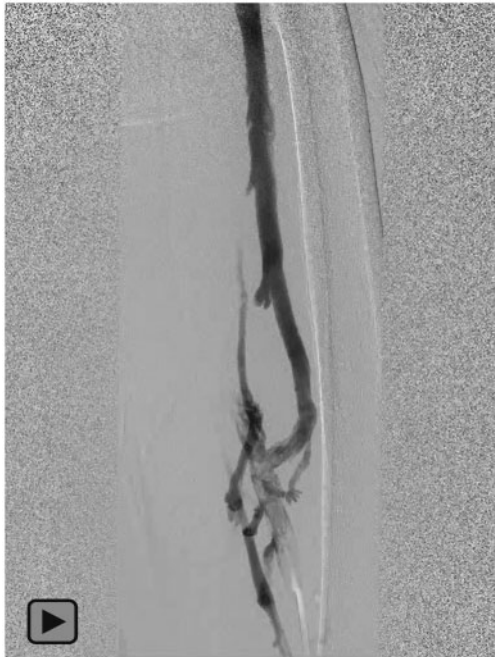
Initial venogram (A) with extensive organized chronic thrombus with significant scarring on intravascular ultrasound imaging (B, C). Post-intervention venogram (D) with improved and patent lumen (E, F).
